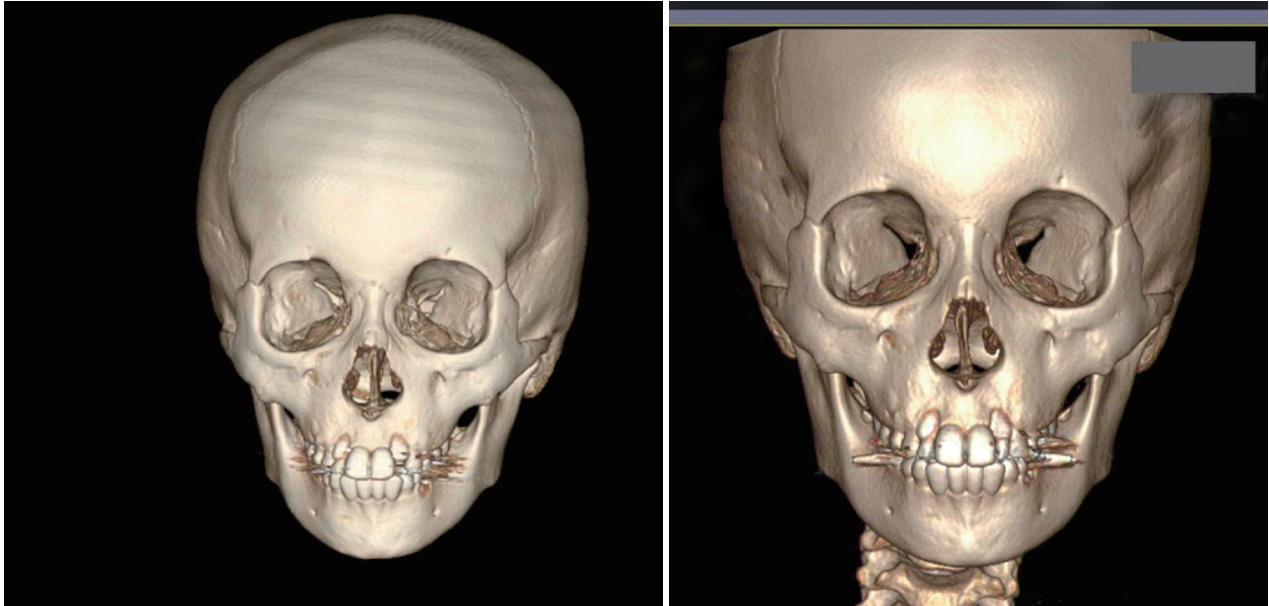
Three-dimensional-computed tomography (3D CT) reconstructed model. It is difficult to use one 3D CT reconstructed image as a reference for another due to the different absolute values generated by differing conditions such as display field of view, tilt, and window, as in the two images shown here.
